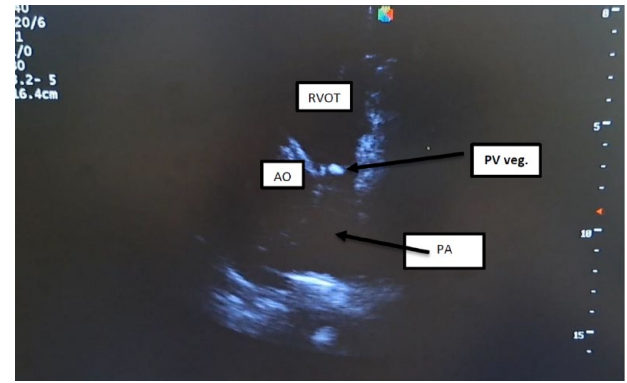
2D parasternal short axis view at the great vessels level showing 12 mm \times 10 mm mobile pulmonary valve vegetation, and mildly thickened pulmonic valves.
